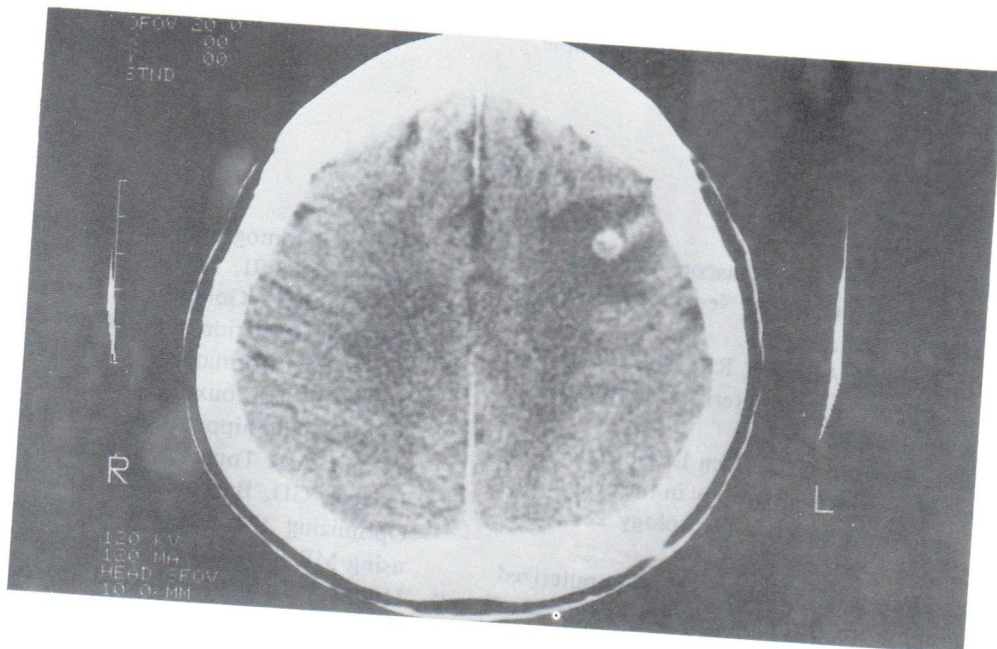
Cysticercosis. I.V. enhanced axial CT scan of the brain, supraventricular level showed small ring enhanced lesion with surrounding white matter edema at corticomedulullary area at high Lt. frontoparietal lobe. Just-dead cysticercotic lesion.
